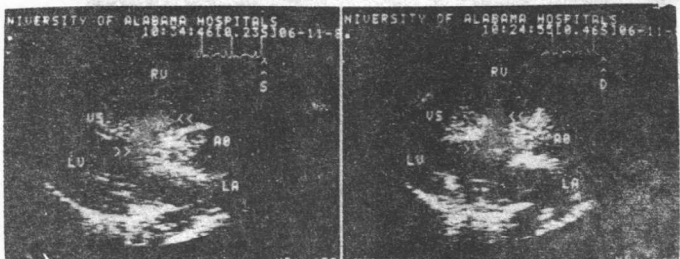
Large ventricular septal defect (*VSD*) with pulmonary hypertension and bidirectional shunting. Long-axis view shows a large *VSD*. The color Doppler documents the presence of bidirectional flow through the *VSD*. *A*, the flow is directed into the right ventricle during systole, shown as red with a central blue area due to aliasing. *B*, during diastole, the flow reverses from right to left (*blue area*).
